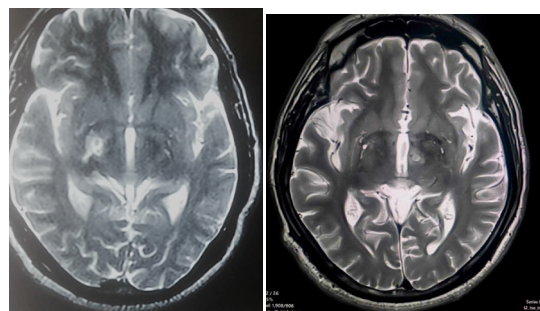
A&B : T2 axial MRI showing right GPi pallidotomy and left PTT lesioning
